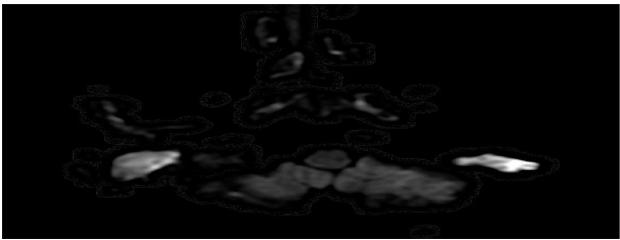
DWI showing diffusion restriction seen bilaterally
